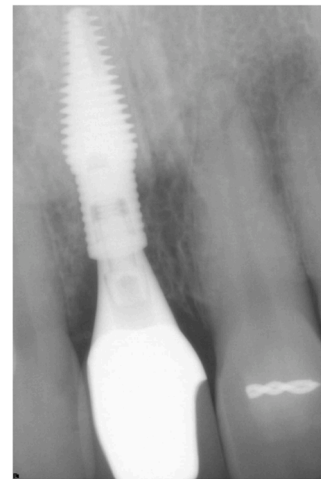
Radiograph at time of crown-delivery. The narrow coronal portion of the implant increases space between the implant and adjacent teeth.
